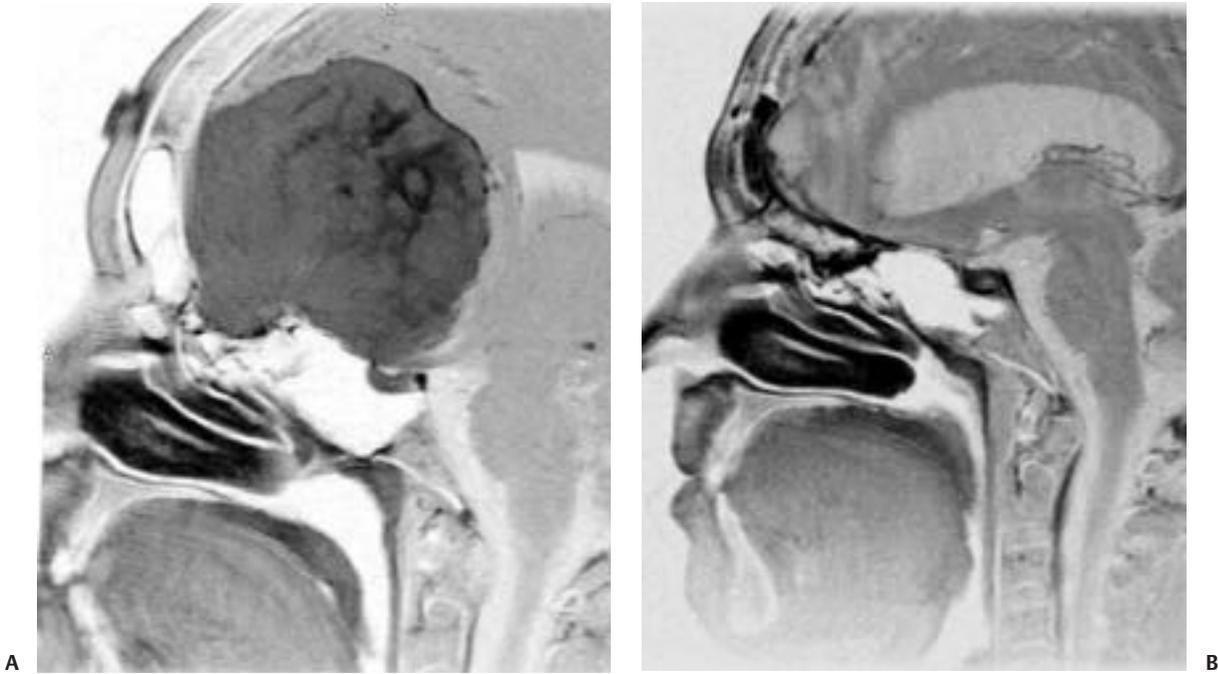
(A) Preoperative and (B) postoperative sagittal postcontrast T1-weighted magnetic resonance images depict complete resection of a huge olfactory groove meningioma. Property of the Department of Neurosurgery, The University of Texas M.D. Anderson Cancer Center. Used with permission.
